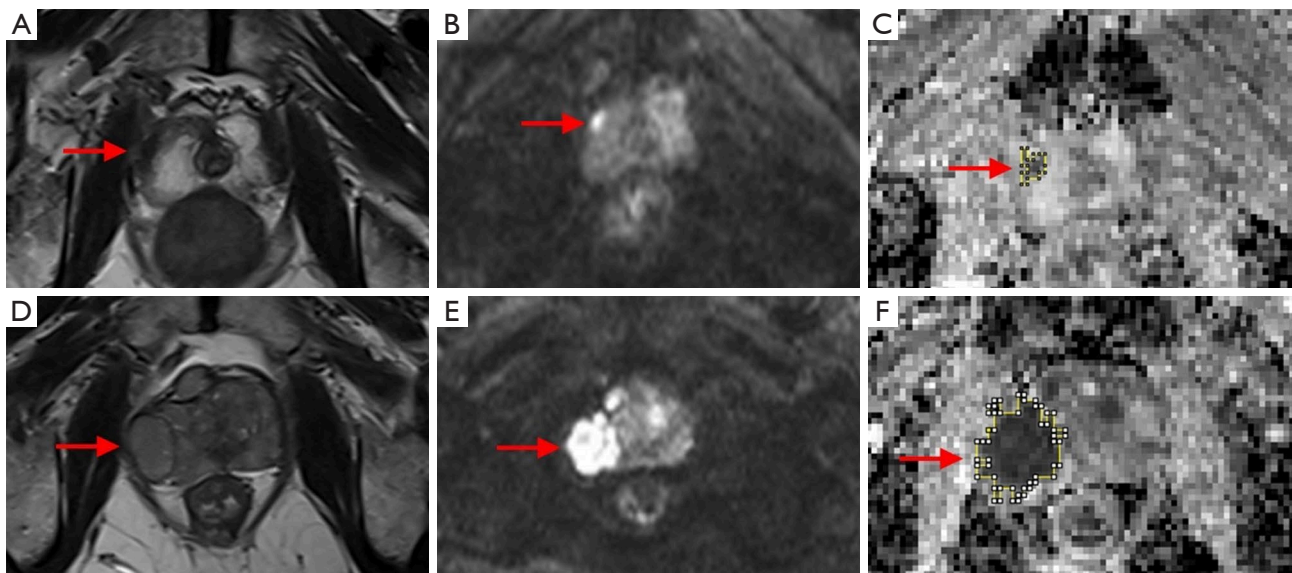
MRI images of PCa and BPH. (A-C) MRI images of BPH patients; (D-F) MRI images of PCa patients. (A,D) focal, well-defined, low-signal lesions in the right peripheral area on T2WI (red arrow); (B,E) significant high signal on DWI (red arrow); (C,F) significant low signal on the ADC chart (shown as irregular yellow area). MRI, magnetic resonance imaging; PCa, prostate cancer; BPH, benign prostate hyperplasia; T2WI, T2-weighted image; DWI, diffusion-weighted imaging; ADC, apparent diffusion coefficient.
